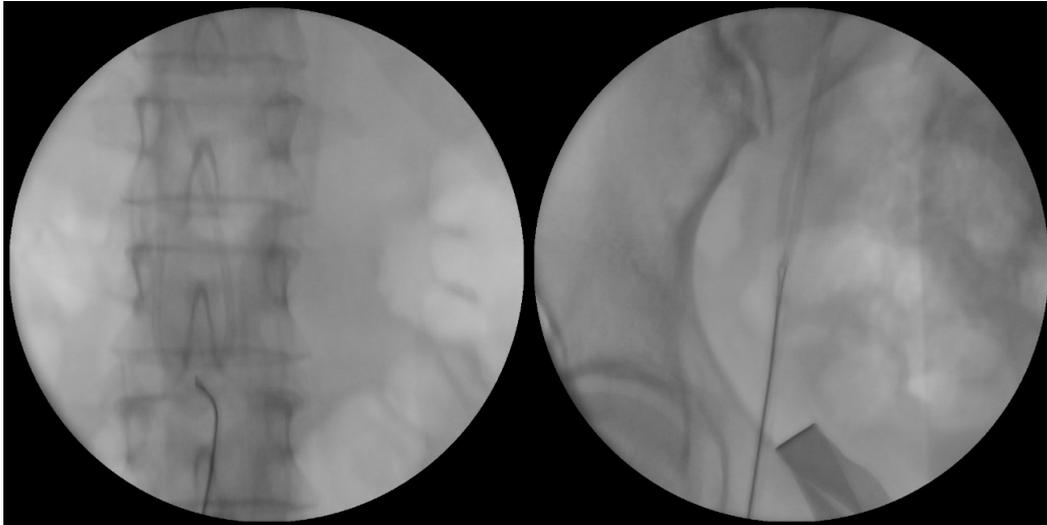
Contrast-enhanced X-ray during reservoir catheter extraction by hemodynamics.
